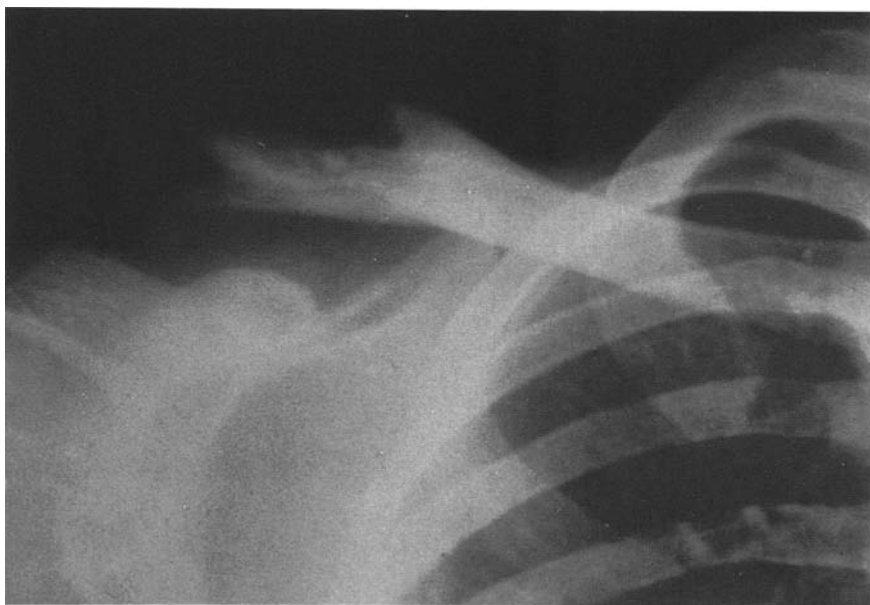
Cystic defect in the structure of the lateral part of the right clavicle (first X-ray evidence of the tumour, June 1978)
